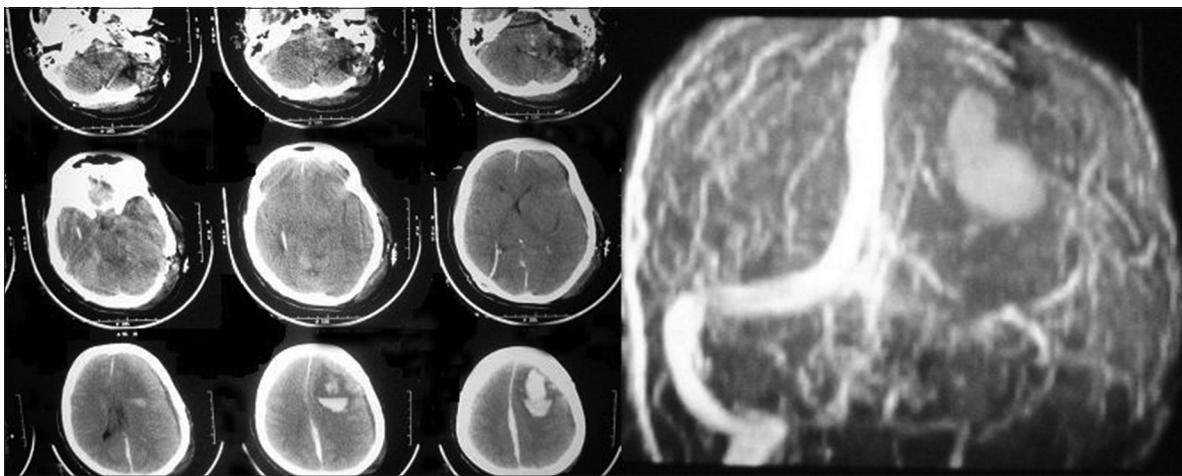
CT scan 12 hours postsurgery showing large left frontal hematoma. Tumor bed shows no changes as compared to immediate postoperative CT scan. Adjacent image is of MRV showing thrombosis of the transverse and sigmoid sinus
